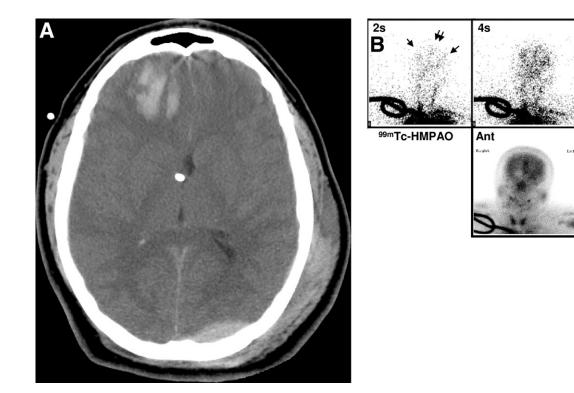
A 19-year-old man after a motorcycle accident with clinical evidence of brain death. (A) Noncontrast CT scan demonstrates a large right frontal lobe contusion and left epidural hematoma of the occiput and posterior fossa with significant mass-effect. A ventriculostomy catheter is seen with its tip in the right foramen of Monro. Other findings on this study not visible at this level include bony fractures, distortion of the left side of the midbrain, and effacement of the supracellar cistern suggestive of incipient supratentorial herniation. (B) Anterior and middle cerebral arterial flow is seen on representative 2-second ^{99m}Tc-HMPAO flow images (arrows), and there is diffuse uptake within the cerebrum and cerebellum on anterior and lateral parenchymal images. Lateral images may be submitted in suboptimal projection due to difficulty in positioning patients with endotracheal tubes and multiple vascular lines.
